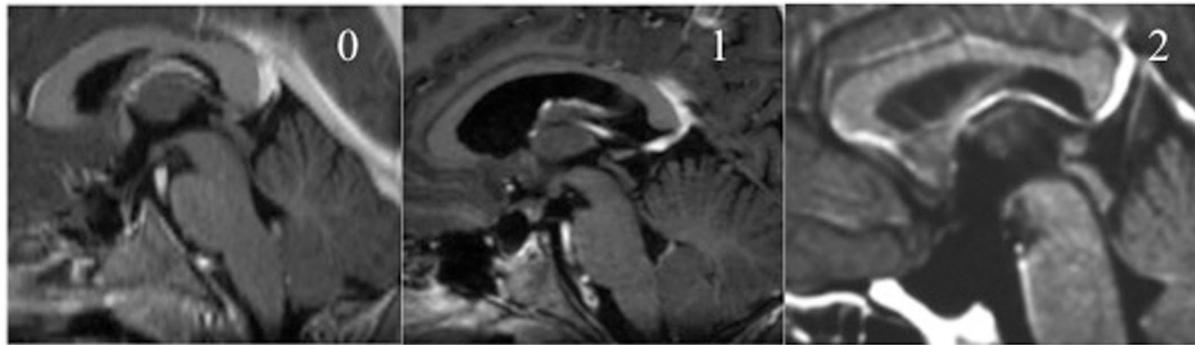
Post-operative MRI classification according to hypothalamic injury. Type 0 post-op: intact hypothalamus, Type 1 post-op: breech/residue on the hypothalamus, Type 2 post-op: severe hypothalamic injury.
